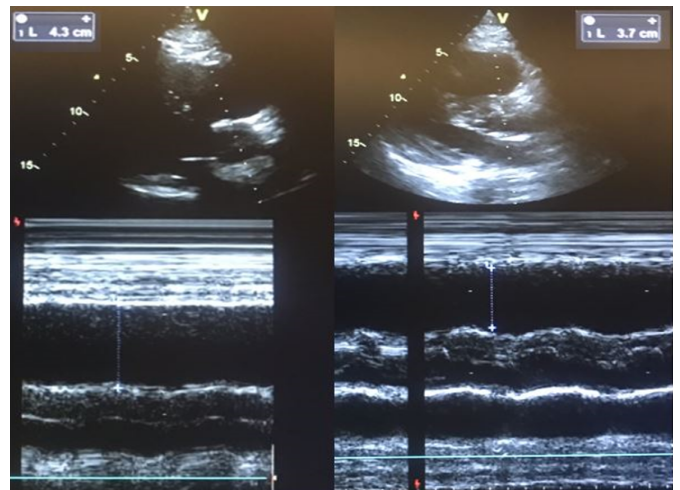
On the left, RV dilatation is depicted in the parasternal long axis view. On the right, a reduction in RV size is observed at 2 hours following thrombolytic treatment
